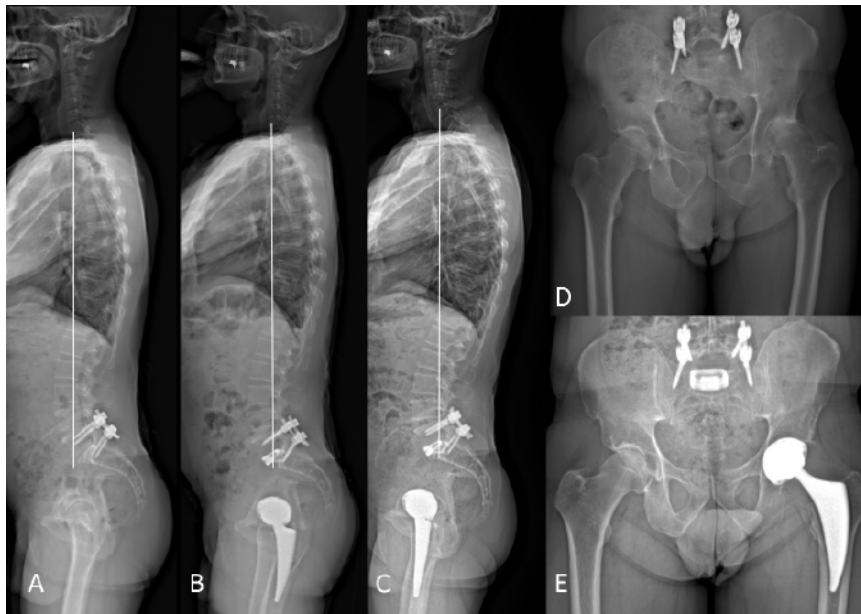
A-D: Pre-operative (A, C) and Post-operative (B, D) frontal and lateral full spine-Xray performed by X-Rays EOS™ and Hip X-Rays. Pre-operative full spine X-Rays (A) showed a type 4 spine shape according to Roussouly classification in previous L5-S1 screws fixation without segmental lordosis restoration or fusion. Post-operative full spine X-Rays control (B) showed correct cage position in L5-S1 ALIF- and segmental lordosis restoration in presence of left AMIS. C: Pre-operative frontal Hip X-Rays revealed 12mm sub-leveling of the right iliac crest. D: Post-operative control revealed the correct position of the left THA with restoration of iliac crest alignment.
